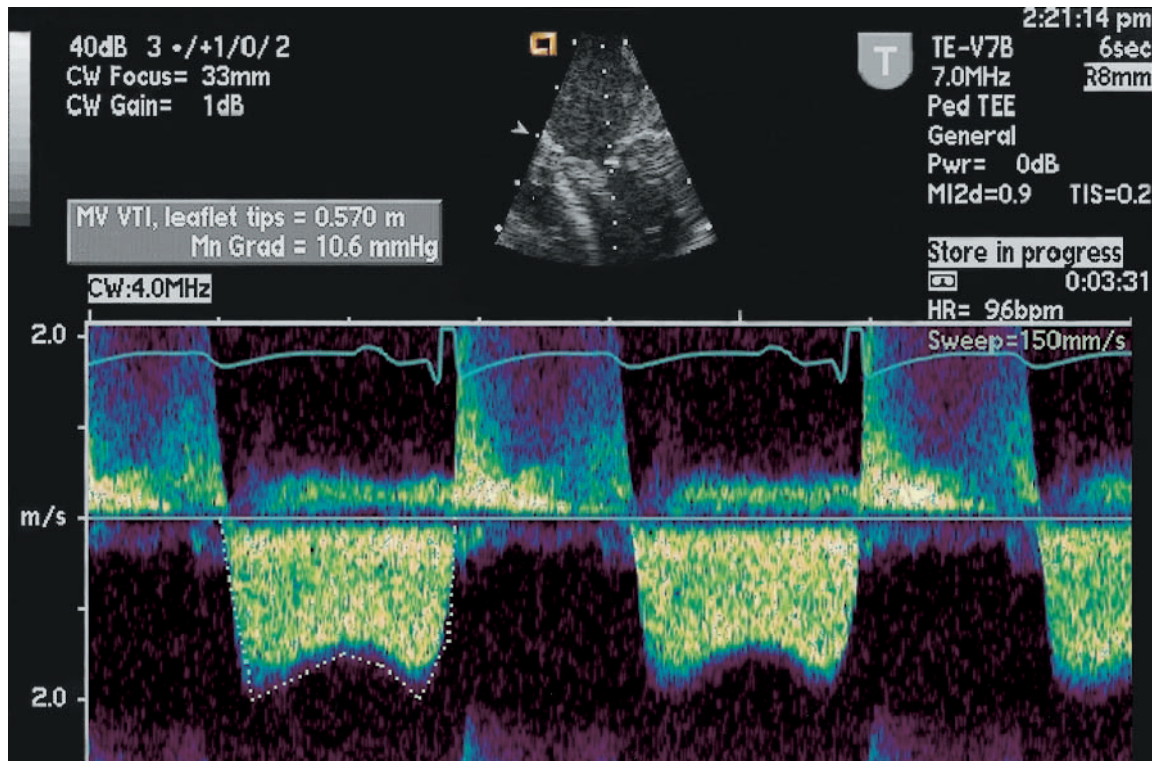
(f) Mitral stenosis. Spectral Doppler interrogation in a patient with moderate to severe mitral valve obstruction demonstrating an estimated mean transmitral gradient of 10.8 mmHg by continuous wave Doppler.
